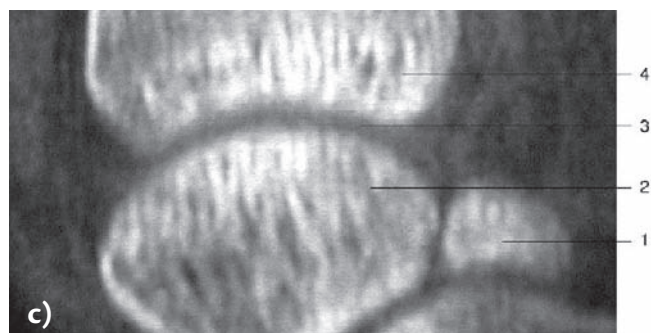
Posterior impingement can be caused by os trigonum. In extreme hyperplantar flexion the posterior bony prominence of the talus may come in conflict with the accessory bone fragment (os trigonum) located just posterior of the talus. This may occur in sports such as gymnastics a) and ballet b); c) computed tomography scan of the talus with os trigonum. 1. Os trigonum 2. talus 3. joint space 4. tibia.
